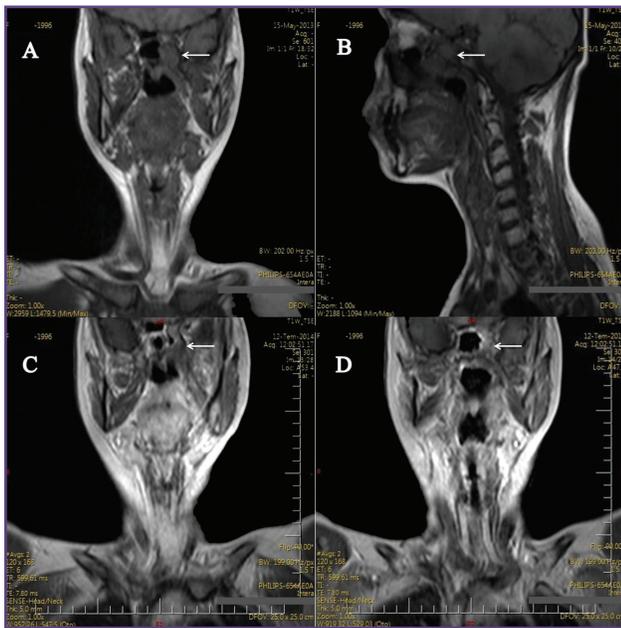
Magnetic resonance imaging (MRI). (A, B) Preoperative MRI. (A) Axial post-contrast T1-weighted MRI showing a nasopharyngeal carcinoma (B) Sagittal T1 weighted MRI. C,D; postoperative MRI and postoperative local radiotherapy. (C, D) Axial post-contrast T1-weighted MRI.
